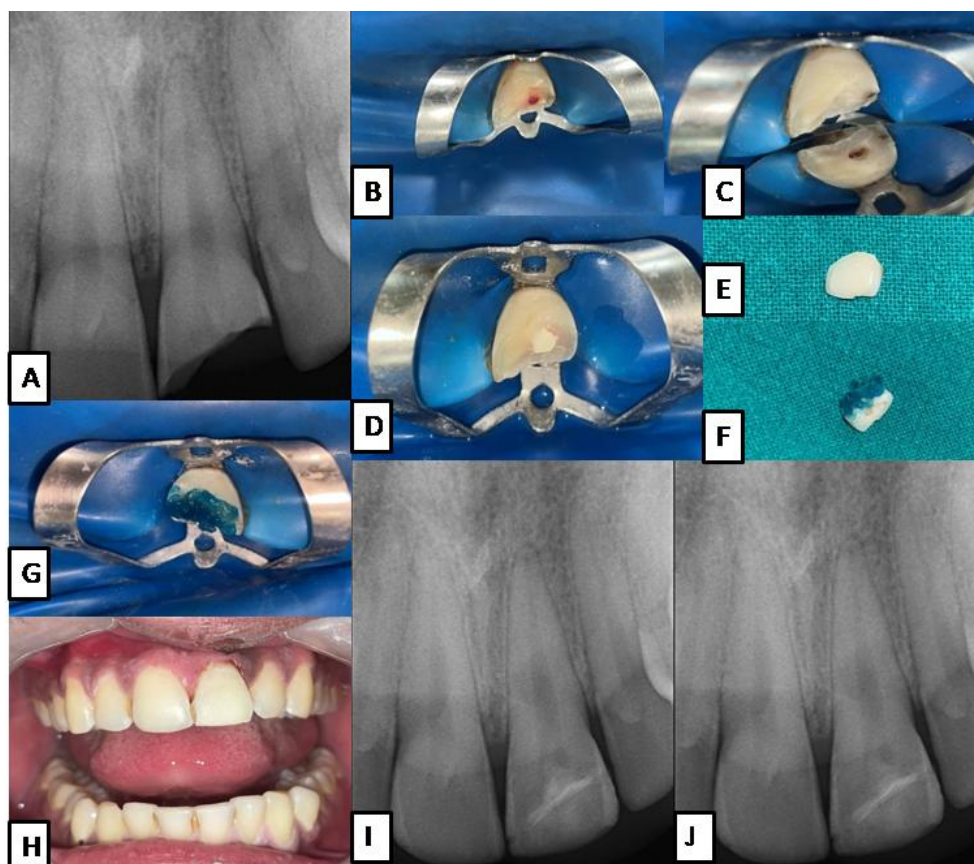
(A) Preoperative Radiograph (B) Preoperative Clinical picture (C) Partial pulpotomy and haemorrhage control (D) Biodentine placed (E) Fractured segment (F, G) Etched fragment and tooth (H) Post operative clinical picture (I) Post operative radiograph (J) 12 month follow up radiograph
